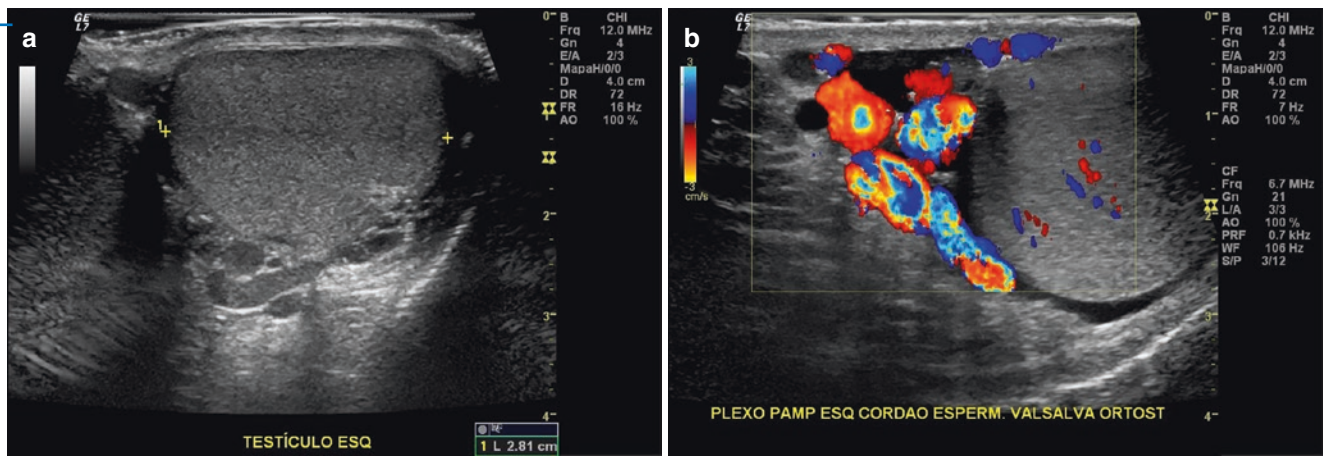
Varicocele Grade 2. (a) B-mode shows dilated veins in the upper pole of the testicle. (b) Color Doppler shows reflux in the pampiniform vein during Valsalva
